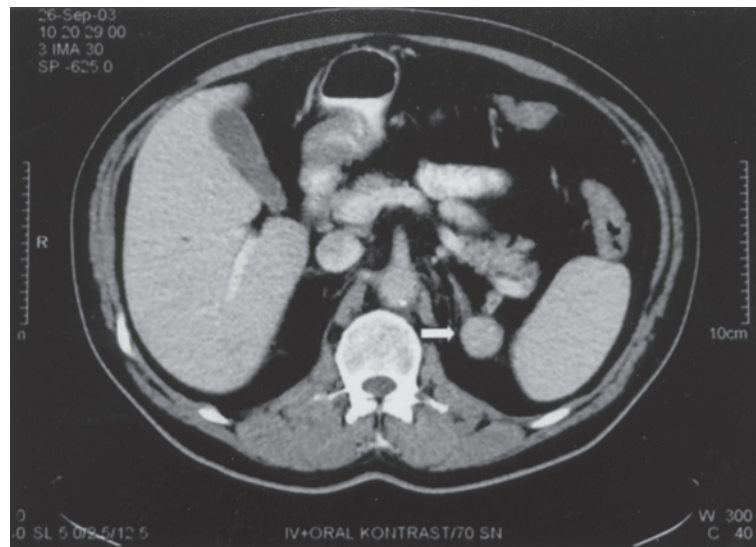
Contrast-enhanced axial CT scan shows a solid homogeneous tumor at the left adrenal gland (arrow).
